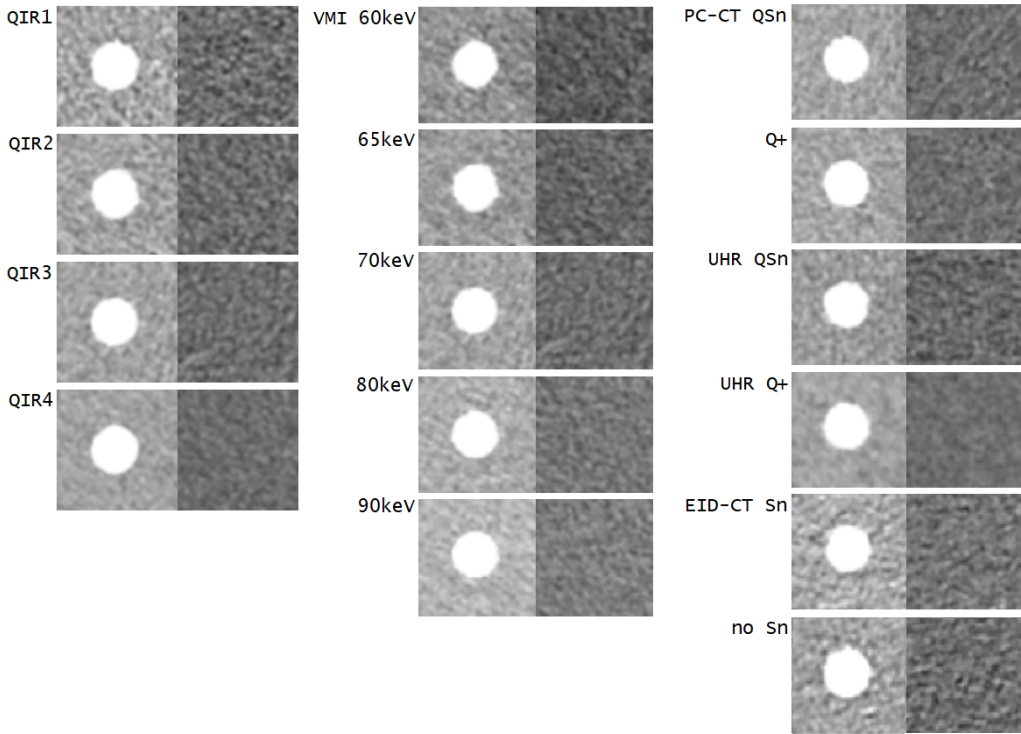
Different levels of IR, VMI keV and scan modes on image quality in PC-CT and EID-CT. The Delrin insert (left) and homogeneous area (right) were used for calculating TTF and NPS, respectively. Images of Br kernel with W/L-settings: W 400, L 40.
